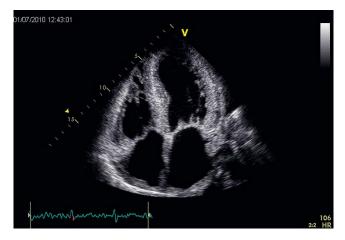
Transthoracic echocardiography demonstrating typical morphological findings in a patient with amyloid cardiomyopathy: the walls of non-dilated LV are concentrically thickened with increased echogenicity of the myocardium; thickening of RV free wall as well as of both dilated atria and interatrial septum is also seen; considerable thickening of mitral and tricuspid valve cusps is present (apical 4-chamber view). LV – left ventricle; RV – right ventricle.
